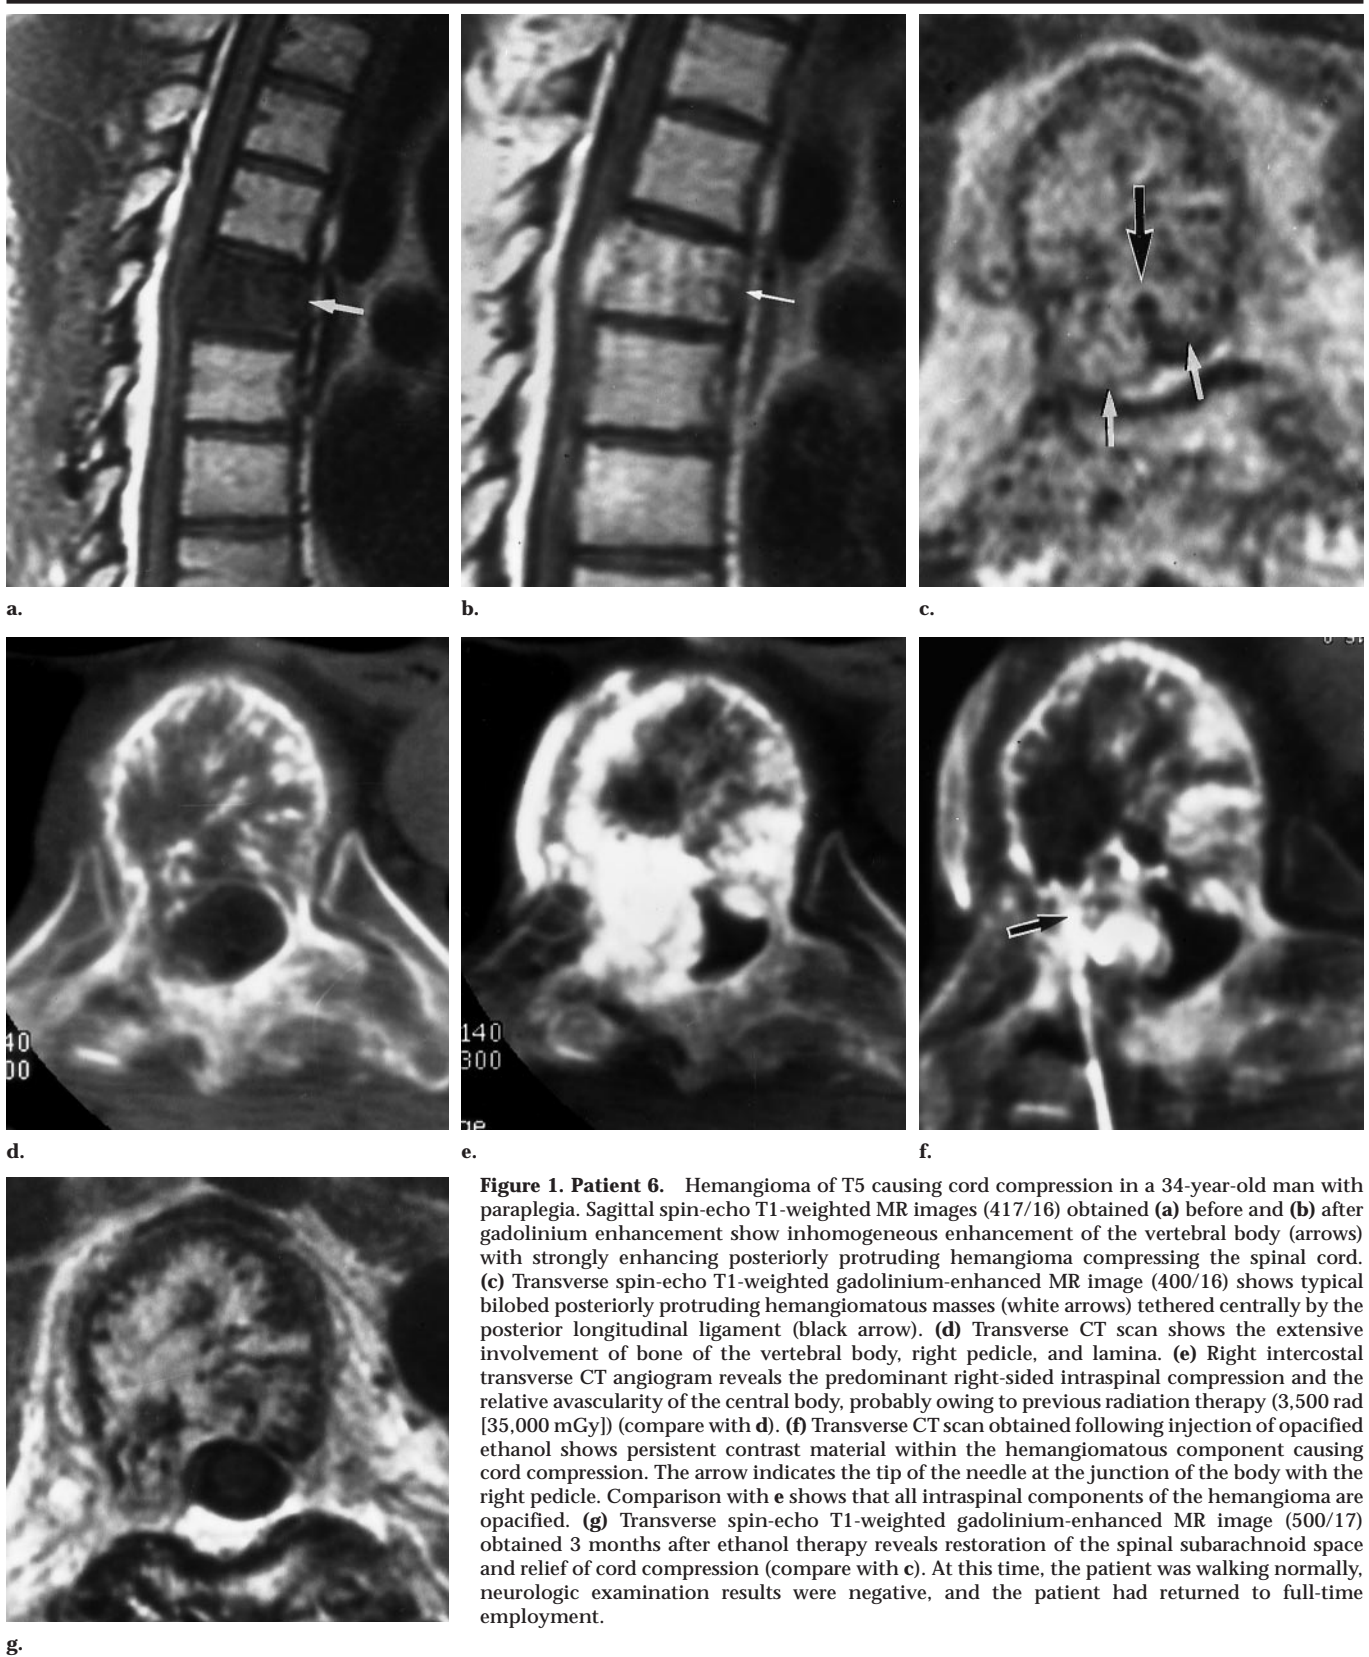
Patient 6. Hemangioma of T5 causing cord compression in a 34-year-old man with paraplegia. Sagittal spin-echo T1-weighted MR images (417/16) obtained (a) before and (b) after gadolinium enhancement show inhomogeneous enhancement of the vertebral body (arrows) with strongly enhancing posteriorly protruding hemangioma compressing the spinal cord. (c) Transverse spin-echo T1-weighted gadolinium-enhanced MR image (400/16) shows typical bilobed posteriorly protruding hemangiomatous masses (white arrows) tethered centrally by the posterior longitudinal ligament (black arrow). (d) Transverse CT scan shows the extensive involvement of bone of the vertebral body, right pedicle, and lamina. (e) Right intercostal transverse CT angiogram reveals the predominant right-sided intraspinal compression and the relative avascularity of the central body, probably owing to previous radiation therapy (3,500 rad [35,000 mGy]) (compare with d). (f) Transverse CT scan obtained following injection of opacified ethanol shows persistent contrast material within the hemangiomatous component causing cord compression. The arrow indicates the tip of the needle at the junction of the body with the right pedicle. Comparison with e shows that all intraspinal components of the hemangioma are opacified. (g) Transverse spin-echo T1-weighted gadolinium-enhanced MR image (500/17) obtained 3 months after ethanol therapy reveals restoration of the spinal subarachnoid space and relief of cord compression (compare with c). At this time, the patient was walking normally, neurologic examination results were negative, and the patient had returned to full-time employment.
